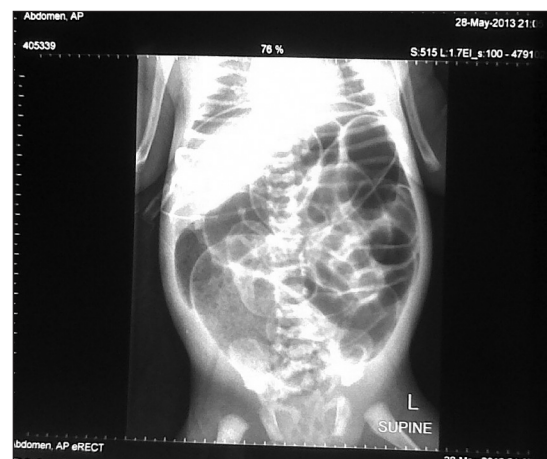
Erect chest/abdominal radiograph and cross table lateral X-ray showing a low anorectal anomaly and pneumoperitoneum
